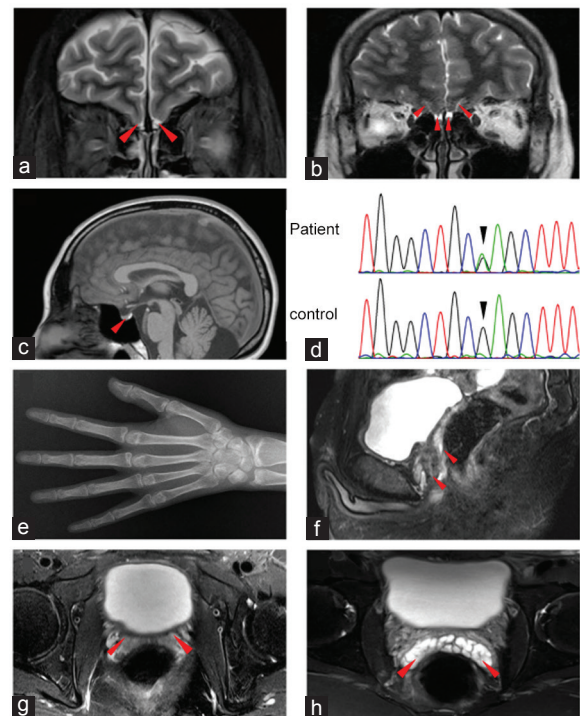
Image characters (a) Fat-saturated coronal T2-weighted MR image shows bilateral agenesis of the olfactory bulbs and tracts (arrows). (b) Coronal T2-weighted MR image shows normal olfactory tracts and bulbs (arrows). (c) Sagittal postcontrast T1-weighted image shows a flat pituitary but no lesion (4 mm height, arrow). (d) Direct sequencing of the *SRD5A2* gene shows c. 680G>A (p.R227Q) substitution at exon 4 in the patient (top arrow) and the sequence of a normal control subject (bottom arrow). (e) X-ray picture of the patient's left wrist shows a 16-year-old bone age. (f) Sagittal T2-weighted MR image shows a Mullerian duct cyst (the upper arrow) and a dysplastic prostate (the lower arrow). (g) T2-weighted axial MR image shows the patient's bilateral agenesis of seminal vesicles. (h) Axial T2-weighted MR image shows normal seminal vesicles. MR: magnetic resonance.
